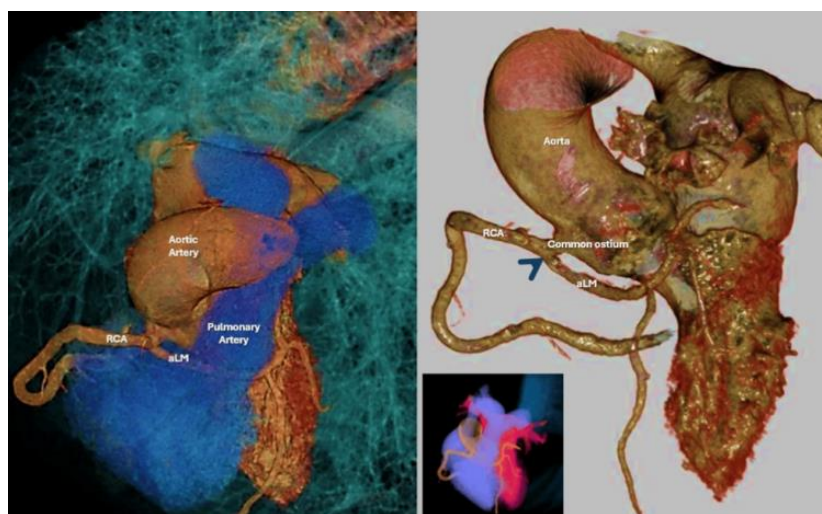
Coronary CTA 3D reconstruction. The blue arrow shows the left main coronary artery has a common ostium with right coronary artery with a transeptal course running in between the aortic and pulmonary arteries.
